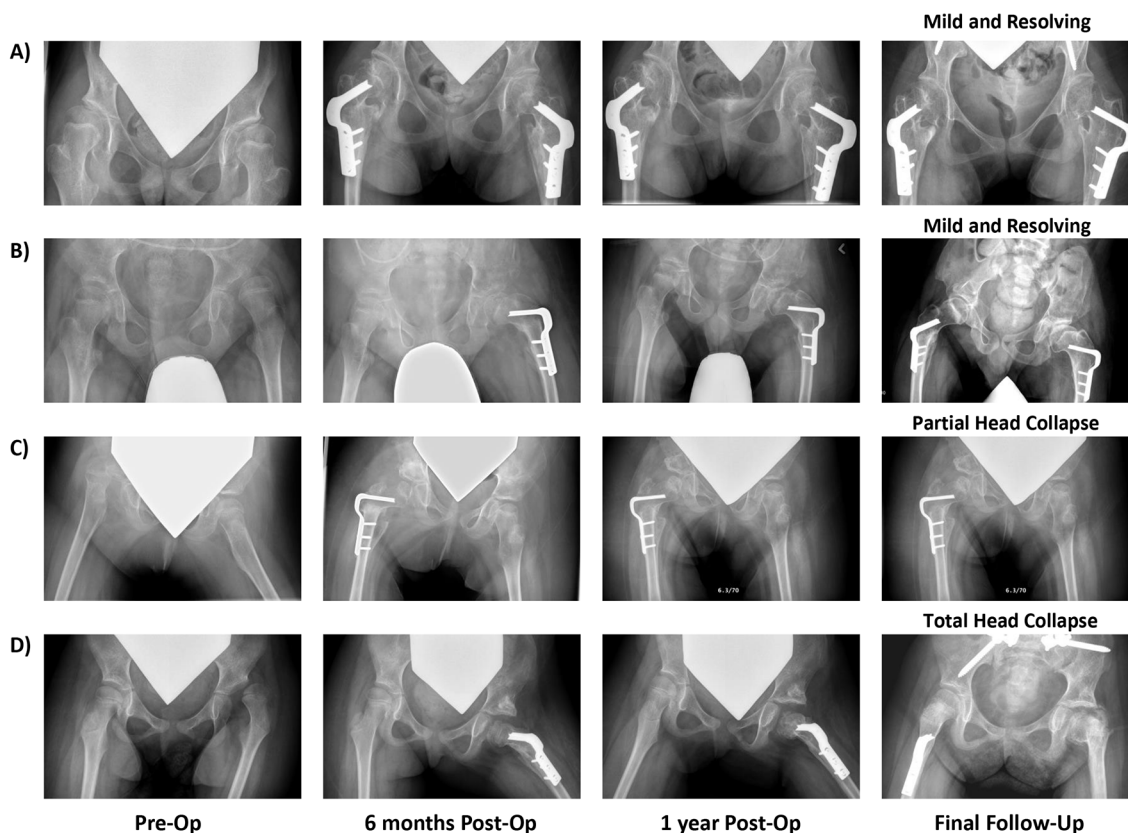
Examples of radiographic avascular necrosis (AVN) progression following varus derotation osteotomy (VDRO), depicting (A) resolution of AVN, (B) mild AVN, (C) AVN with partial head collapse and (D) AVN with total head collapse; all at final follow-up.
